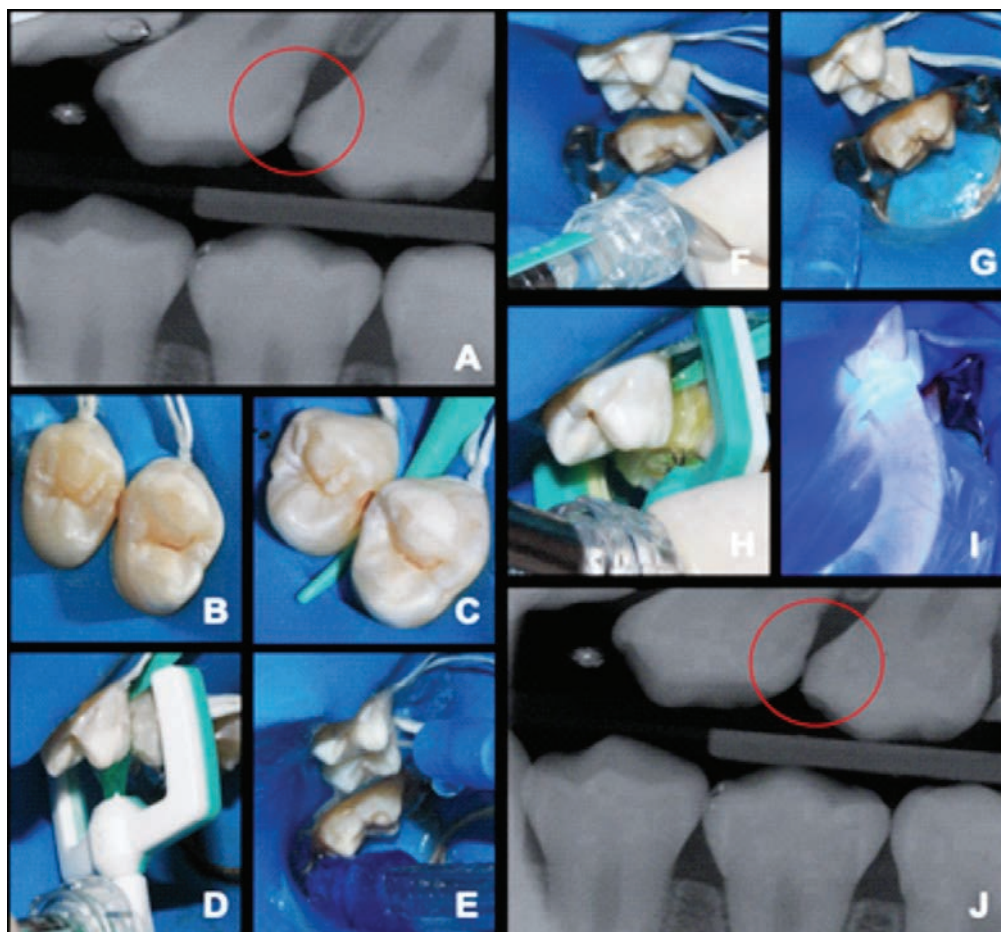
Resin infiltration technique of the proximal caries lesion on teeth 24 and 25 ICDAS 2. A) Initial interproximal radiography. B) Isolation with rubber dam. Non-cavitated caries lesion in enamel is observed on the distal surface of the tooth 24 and mesial of the tooth 25; C) Separation wedge inserted into the interproximal region; D) Icon-Etch syringe, introduced with the green face of the arch and the pores facing to the surface of the proximal lesion to be treated; E) Removal of the gel with water and air jets; F) Icon-Dry syringe; G) Removal of the material with water and air jets; H) Icon-Infiltrant syringe into the approximal region; I) Light-curing; J) Interproximal radiography after 1 month follow-up showing the sealing of the non-cavitated carious lesion in the enamel by the resinous infiltrate (Icon®).
